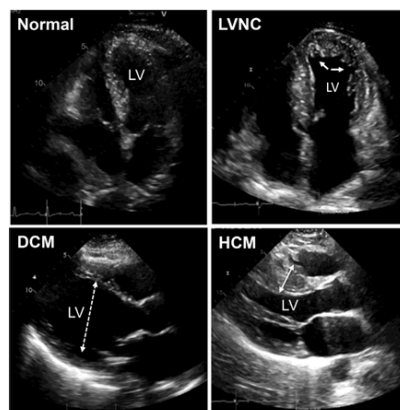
Echocardiography showing forms of cardiomyopathy. Left ventricular noncompaction cardiomyopathy (LVNC) is shown in the upper right (arrow indicates deep trabeculation in the left ventricle [LV]). Dilated cardiomyopathy (DCM) is defined by an enlarged LV diameter (dashed double arrow). Hypertrophic cardiomyopathy (HCM) is defined by thickening of the LV, including the septum (marked with double arrows)⁵
